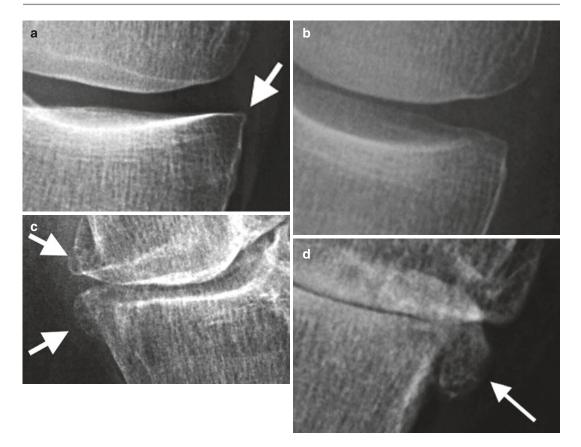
Osteophyte on radiograph, (a) early osteophyte formation medial margin of the medial tibial plateau, (b) normal example for reference, (c) moderate and (d) large osteophytes (*arrows*)
